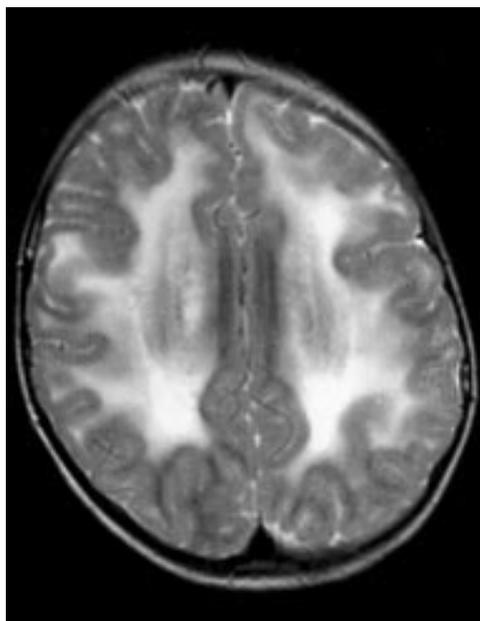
Cerebral MRI scan (T2 weighted image) of case 3 showing widespread T2 hyperintensity of white matter.
